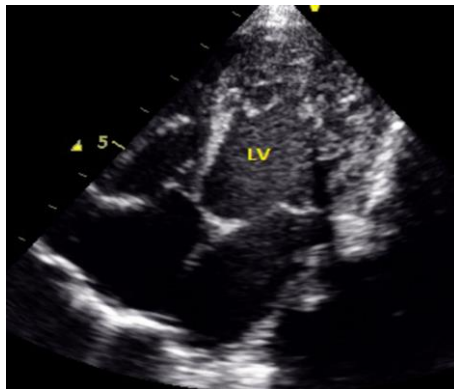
Two-Dimensional Echocardiogram In Apical Four Chamber View Showing Left Ventricle And Prominent Trabeculations With Sinuses Consistent With Noncompacted Myocardium Of The Lateral Wall.
